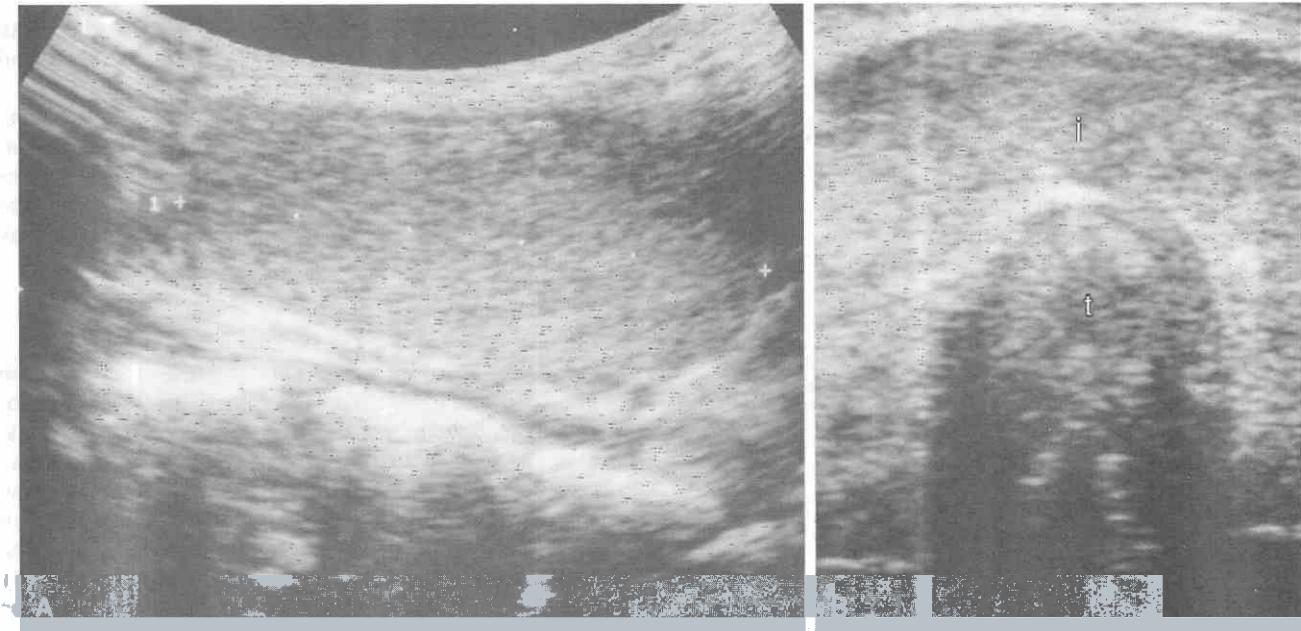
A, Sagittal ultrasound image of the right thyroid lobe shows an enlarged lobe with homogeneous, slightly hypoechoic echotexture. No focal nodules, cysts, or calcifications are noted in this patient with Hashimoto's thyroiditis. B, Transverse ultrasound image shows homogeneous, hypoechoic parenchyma with enlargement of the thyroid isthmus (i) as well as both lobes. The centrally located trachea (t) demonstrates artifact posterior to it generated by internal air.
